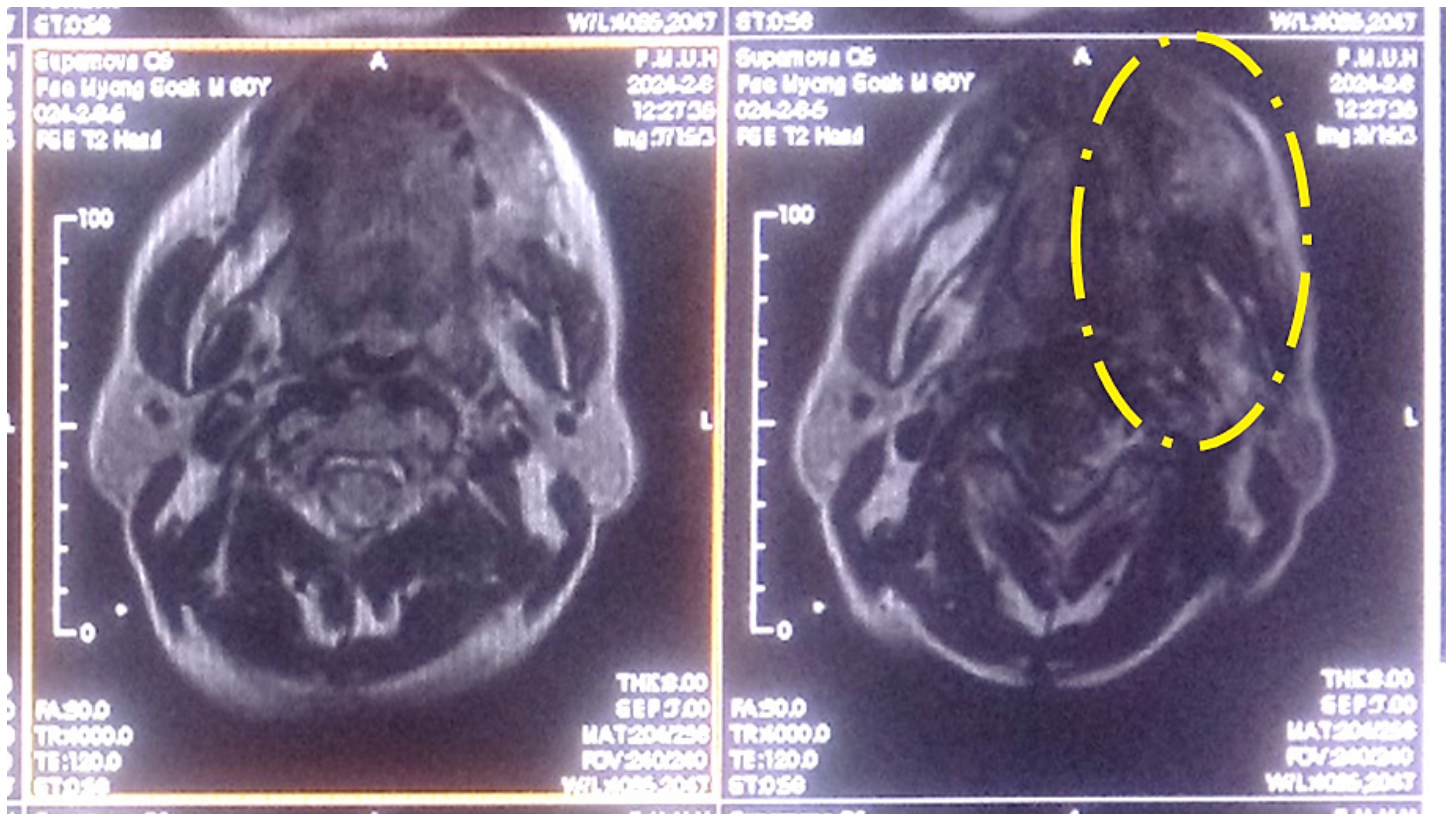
Preoperative MRI (yellow dashed line:tumor lesion).
